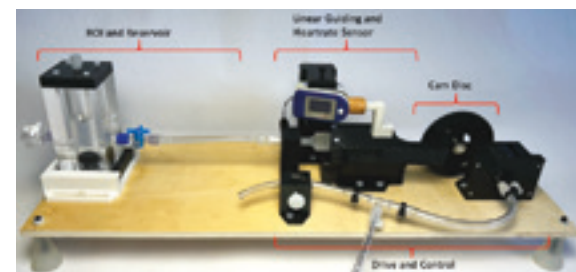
MR-Compatible Pump set-up for PC-MRI validation.
